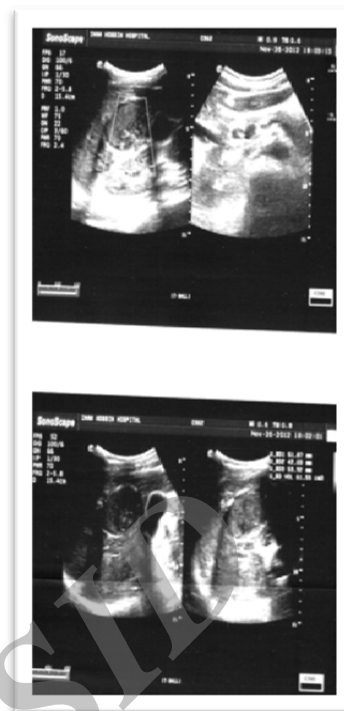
Ultrasound images showed liver hydatid cyst and dilated CBD.
